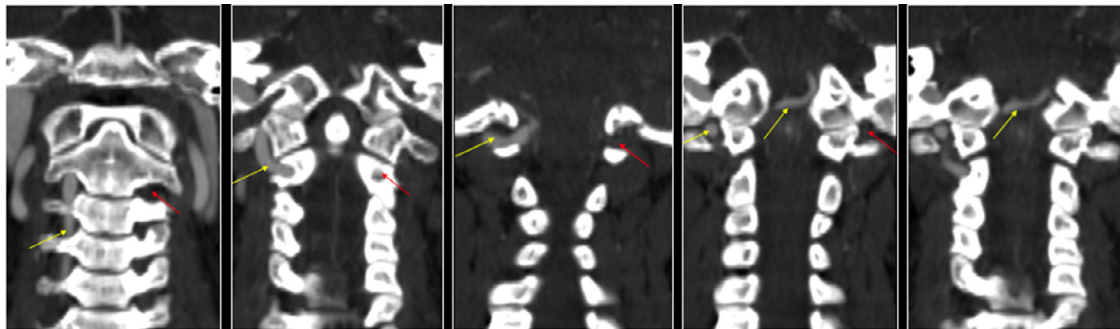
Coronal sequences from anterior to posterior of a neck CT angiography: The yellow arrows indicate the course of the right vertebral artery until it enters the base of the skull as a single artery to form the basilar artery. Red arrow indicates the absence of the left vertebral artery.
